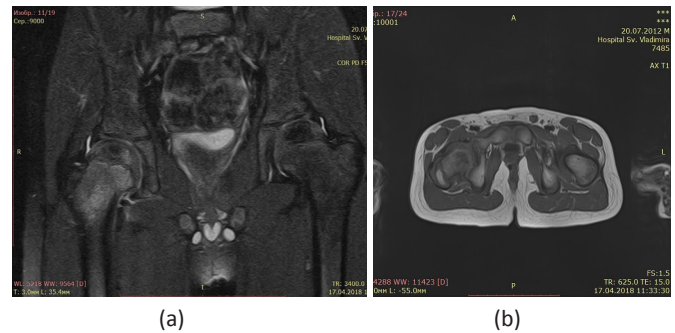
MRI, PD Fat Sat, frontal view (a), T1, axial view (b): LCPD, right side, stage II.
